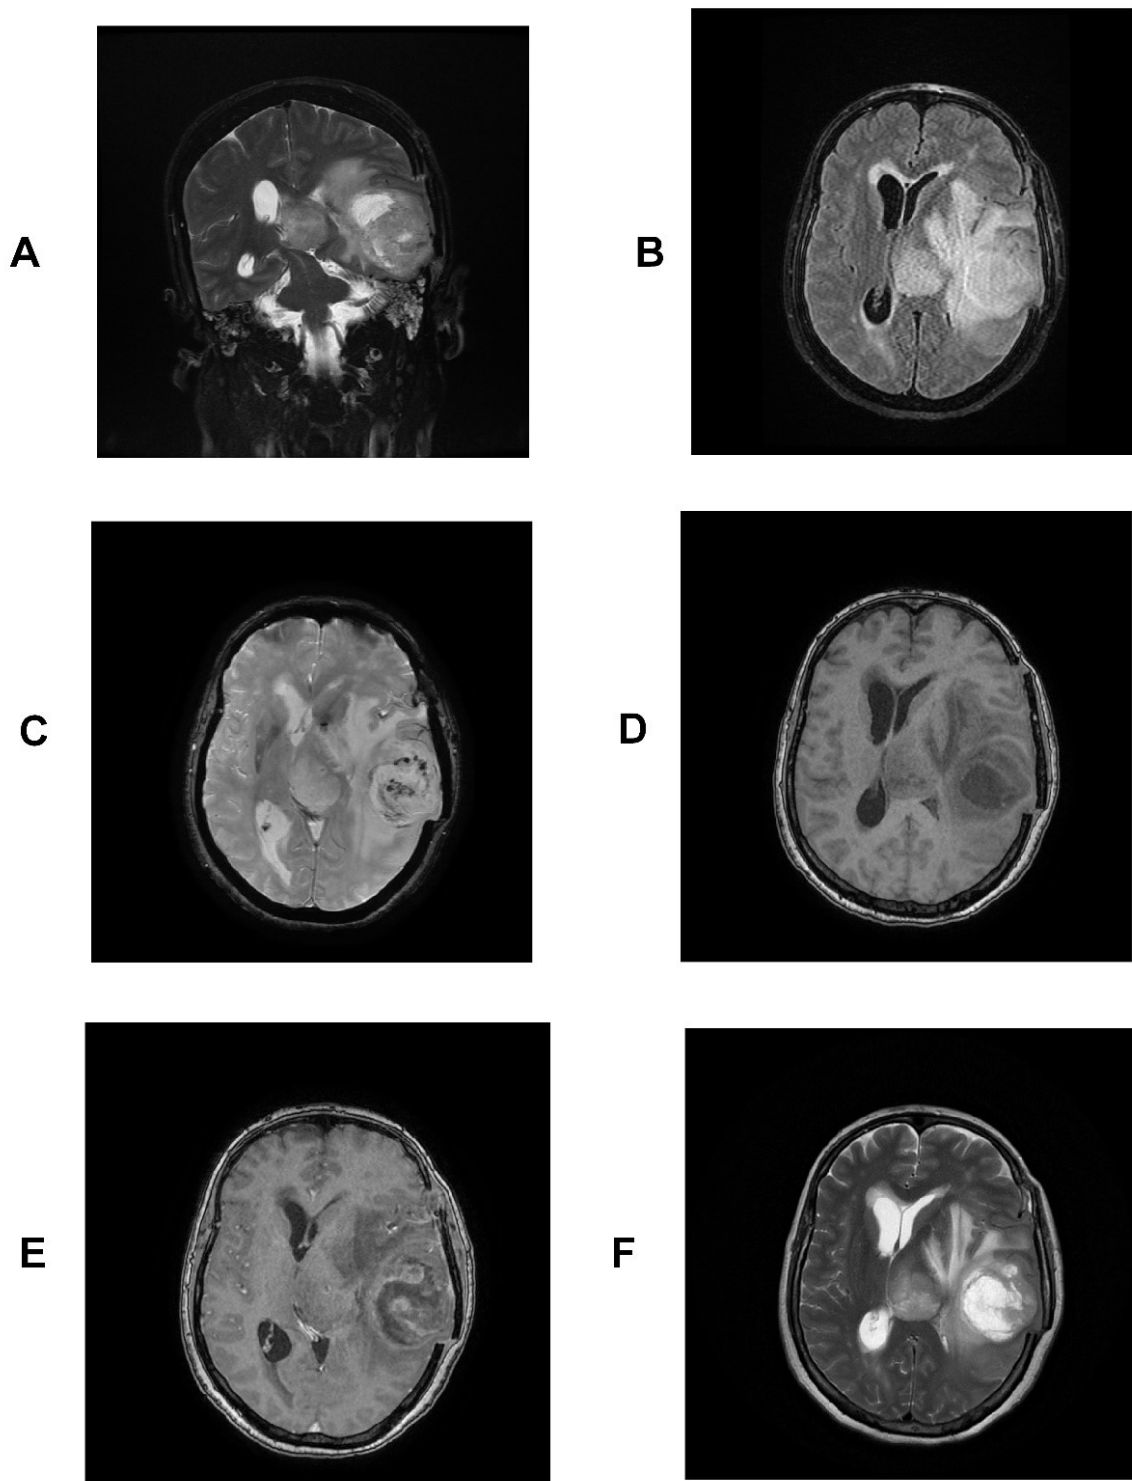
Representative images for the magnetic resonance imaging (MRI). A multi-sequential MRI confirmed the presence of two large intra-axial lesions. The largest lesion was noted at the left temporal lobe, demonstrating a central fluid-like signal intensity in the T2-weighted MRI sequence (A,F) and avidly enhancing the thick, irregular wall in the T1 post-contrast image (E). A few dark foci were observed within the lesion in the GRE sequence (C), consistent with a blooming artifact, likely indicating hemorrhage or small calcifications. Moderate surrounding vasogenic edema was observed, which caused a mass effect on the effacement of adjacent sulci and the ipsilateral posterior horn of the lateral ventricle. The other lesion was observed in the left thalamus and showed intermediate T2/fluid-attenuated inversion recovery (FLAIR) signal intensity (A,B,F). It showed no significant enhancement in the T1 post-contrast image (D). The lesion compressed the third ventricle and caused a mild right-sided midline shift (F). Overall, MRI features were consistent with two aggressive neoplastic lesions.
